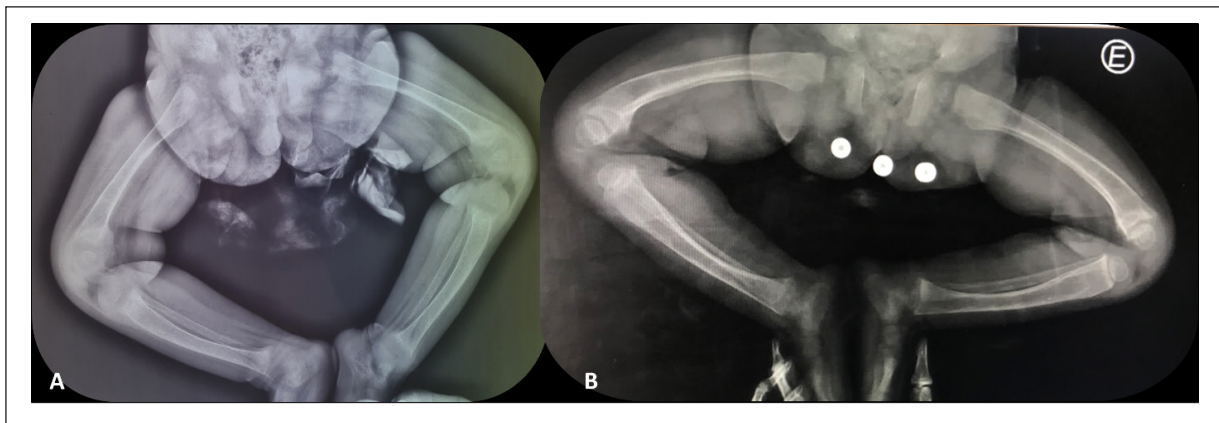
Radiographic changes before and after treatment. A: pre-treatment radiograph of the lower limbs and hip, showing loss of definition and epiphyseal widening, with no visible ossification centers, diaphyseal deformity, osteopenia, and thin cortex. B: radiograph of the lower limbs after 3 months of treatment, showing improvement in osteopenia, with visible ossification centers, while diaphyseal deformity persists.
